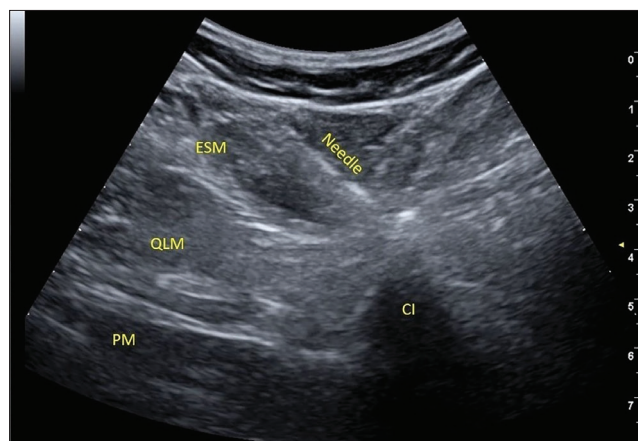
Quadro-iliac plane block-ultrasound view.
